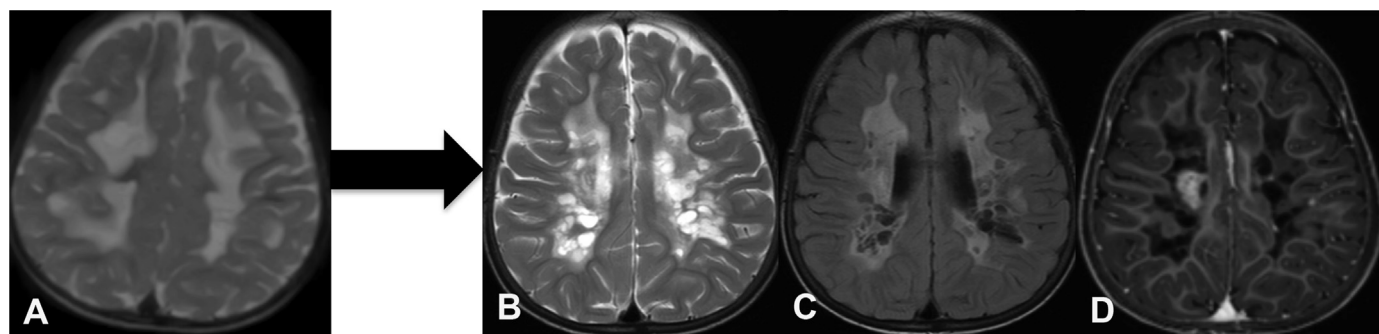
MRI Brain in a 2-year-old child with Mitochondrial leukoencephalopathy and mutations in IBA57 (Patient 14). A) T2W axial image at the time of first presentation shows large asymmetrical confluent white matter signal changes B-D) Follow up study shows rarefied white matter on T2W axial view (B), cysts inside the affected white matter on FLAIR(C), contrast enhancement (D).
